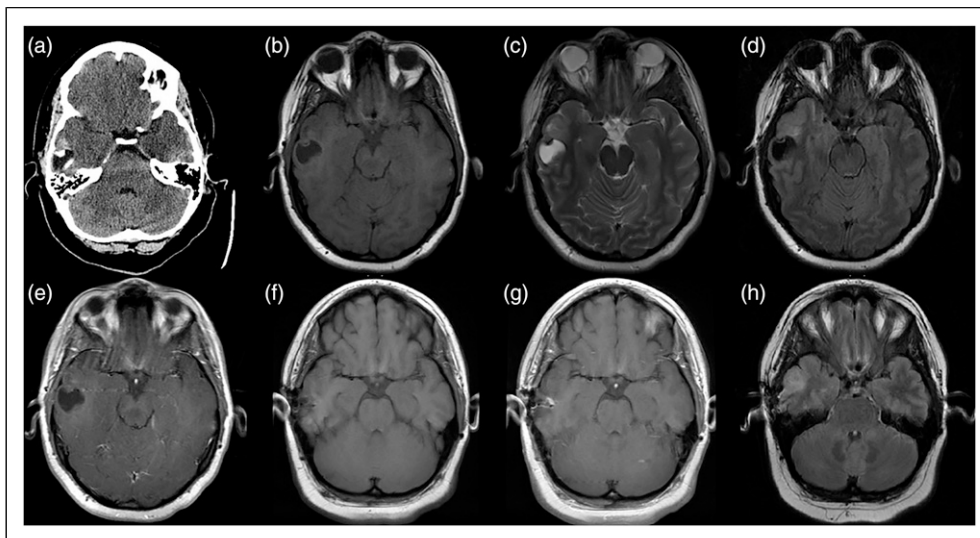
Preoperative axial brain CT (a), T1WI (b), and T2WI (c) without contrast demonstrate $1.8 \times 2.2 \times 1.8$ cm cystic, calcified right temporal mass. Pre-operative T2 FLAIR demonstrates a FLAIR abnormality just anterior to the mass (d). Post-contrast T1 axial MRI was non-enhancing (e). Postoperative T1 FSE axial MRI pre-contrast (f) and post-contrast (g) have no findings suggestive of recurrence. Postoperative T2 FLAIR redemonstrates the FLAIR abnormality just anterior to the resection cavity (h).
